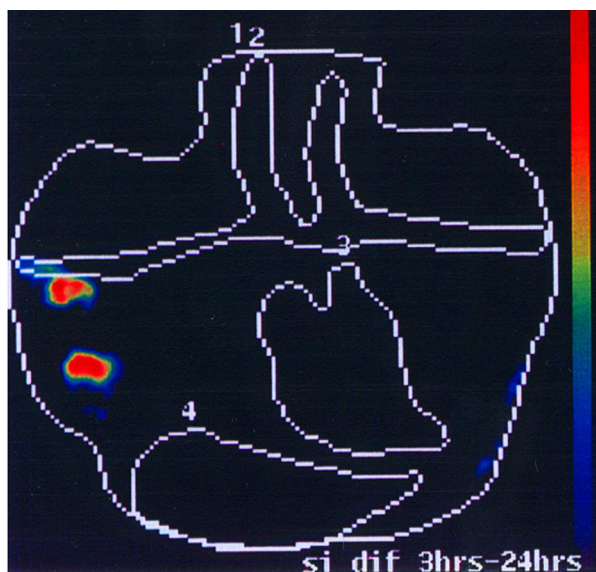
Tc99m hHMFG-1 radioimmunoscintigraphy. Positive right axillary nodes and breast cancer (figure courtesy of Professor K E Britton, St Bartholomew's Hospital; reproduced by permission from: *Br J Cancer* 2002; 86: 870–8).
